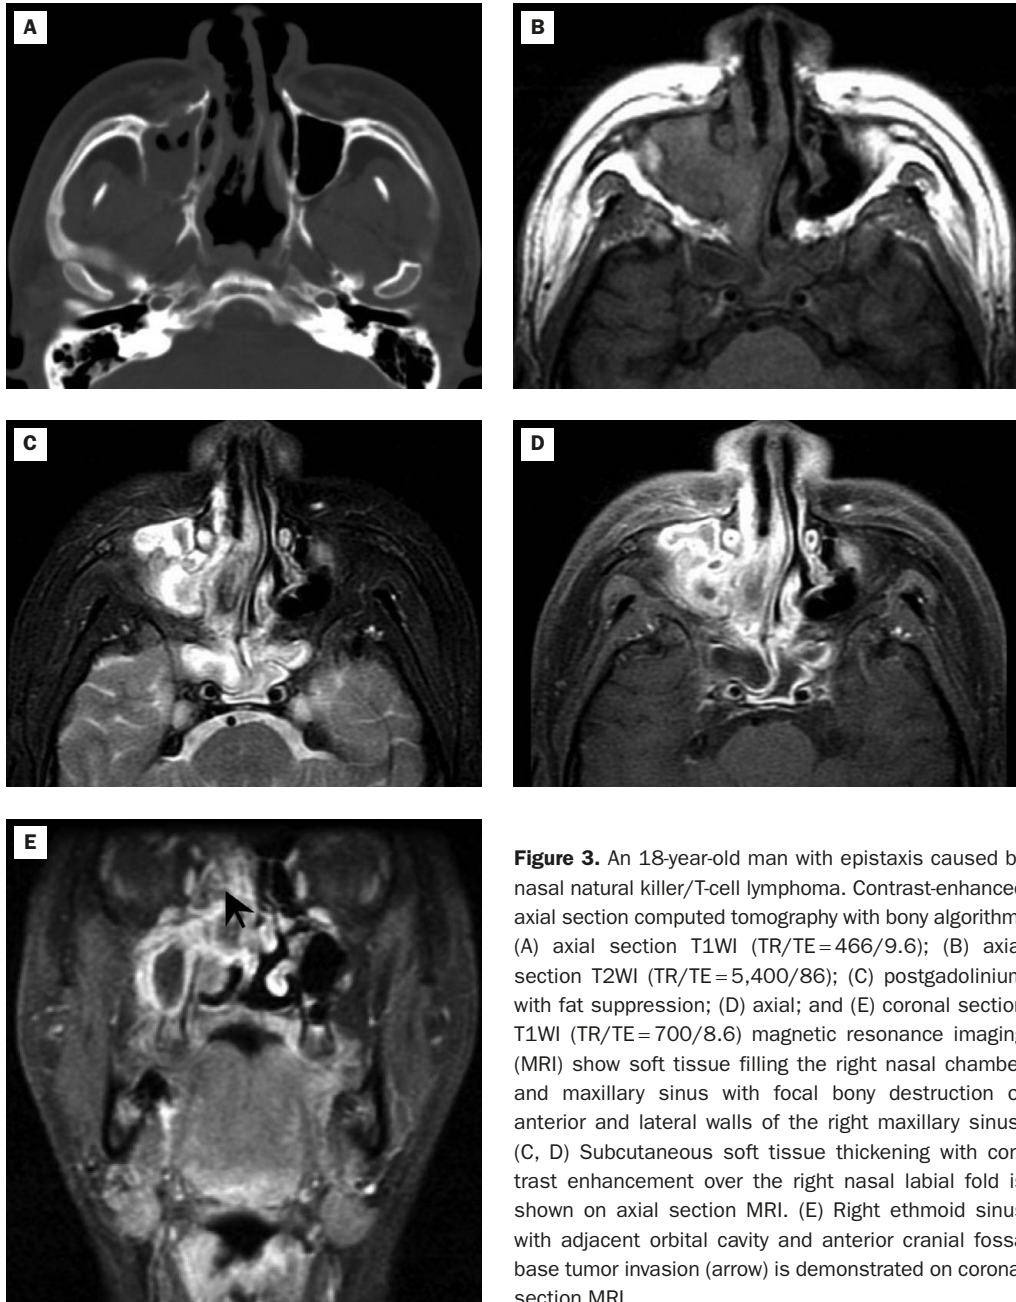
An 18-year-old man with epistaxis caused by nasal natural killer/T-cell lymphoma. Contrast-enhanced axial section computed tomography with bony algorithm: (A) axial section T1WI (TR/TE=466/9.6); (B) axial section T2WI (TR/TE=5,400/86); (C) postgadolinium with fat suppression; (D) axial; and (E) coronal section T1WI (TR/TE=700/8.6) magnetic resonance imaging (MRI) show soft tissue filling the right nasal chamber and maxillary sinus with focal bony destruction of anterior and lateral walls of the right maxillary sinus. (C, D) Subcutaneous soft tissue thickening with contrast enhancement over the right nasal labial fold is shown on axial section MRI. (E) Right ethmoid sinus with adjacent orbital cavity and anterior cranial fossa base tumor invasion (arrow) is demonstrated on coronal section MRI.
